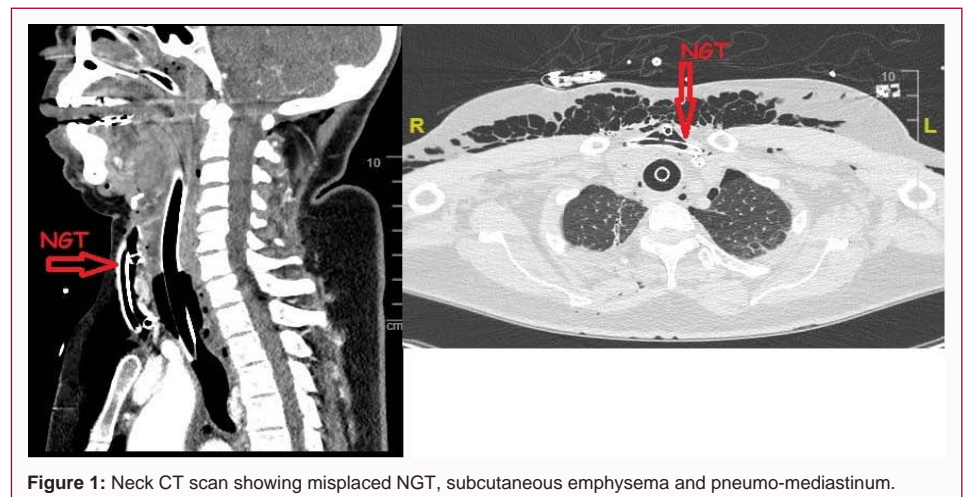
Neck CT scan showing misplaced NGT, subcutaneous emphysema and pneumo-mediastinum.
